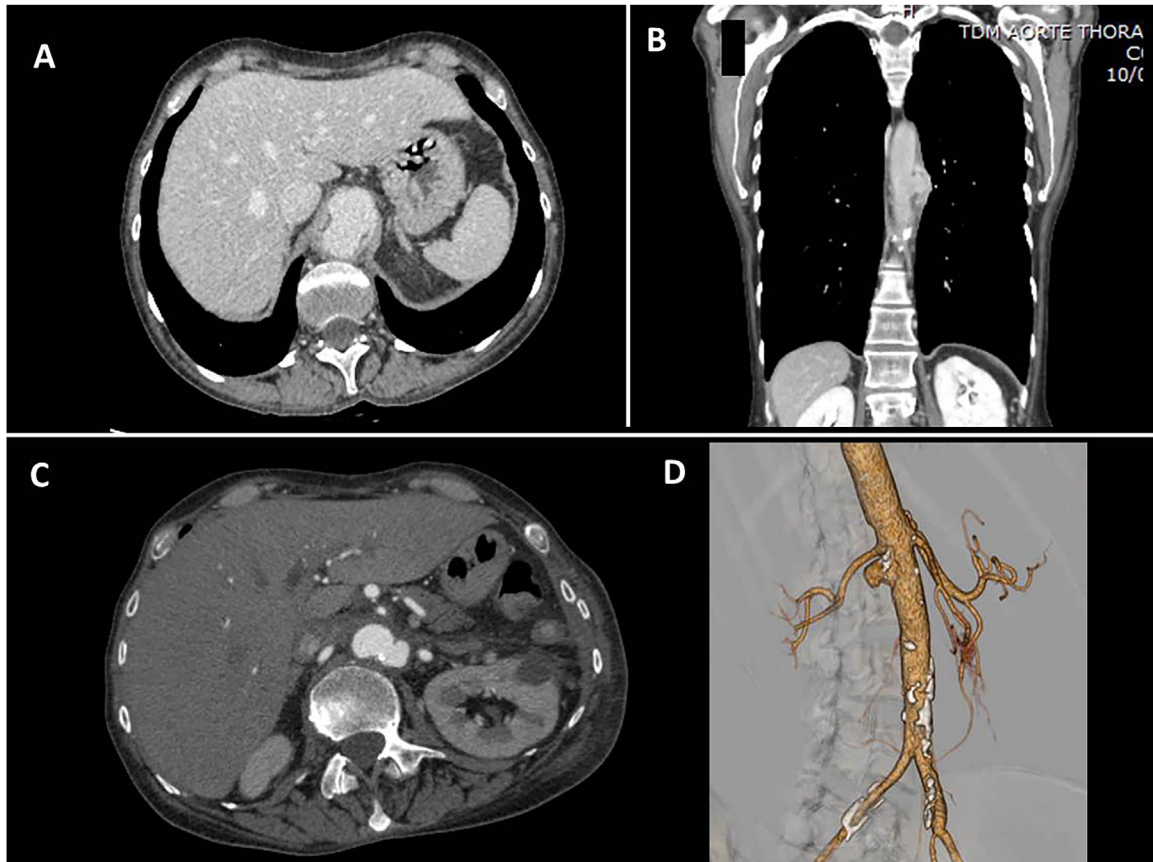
CT angiography. A: Initial CT angiography showing abdominal aortic aneurysm upstream of the coeliac axis ($28 \times 23 \times 29$ mm) in axial view. B: Initial CT angiography finding an aneurysm on the descending thoracic aorta (18×9 mm and 22 mm in height) with an inflammatory aspect as observed in coronal view. C: Control CT angiography 9 days after surgery showing an increase in size of the abdominal aorta infrarenal aneurysm ($10 \times 8 \times 10$ mm) in axial view. D: Control CT angiography 3-dimensional reconstruction.
